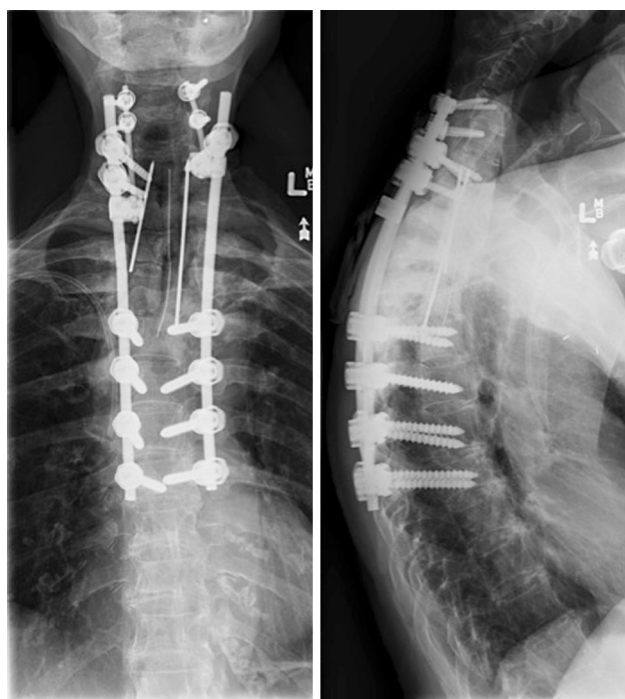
Follow-up standing thoracic spine X-rays 13 years post initial surgery
